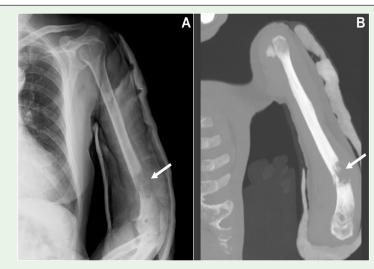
Plain radiograph (A) and computed tomography of left arm showing a pathologic fracture of the distal third of humerus due a to a bone metastases from a thyroid carcinoma.
